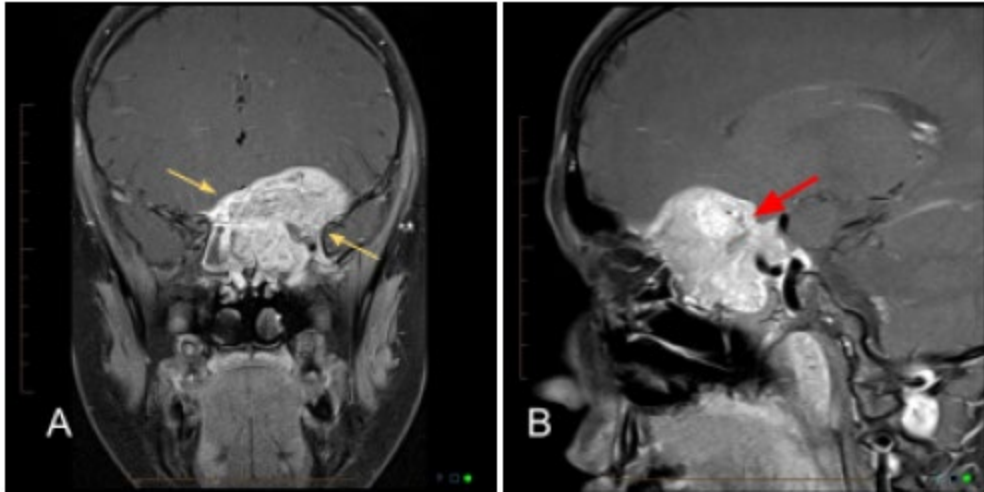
Coronal (A) and sagittal (B) post-contrast enhanced MRI T1 fat-saturated sequences demonstrating a large mass centered in the left sphenoid (yellow arrows) extending into the superior and posterior left orbit with multiple internal flow voids (red arrow). The mass enhances avidly on post-contrast imaging.
